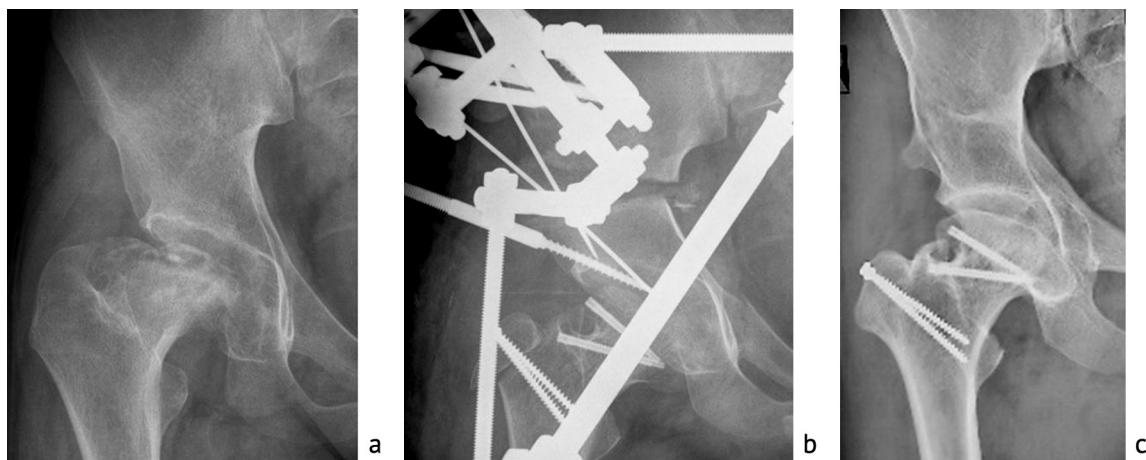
Patient's radiographs: (a) before treatment; (b) reduction osteotomy of the femoral head, osteotomy; (c) 10-year pelvic old outcome
